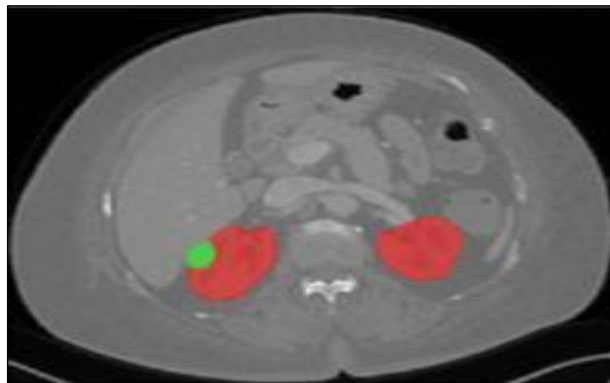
Images from Kits19 Data Collection Exhibiting an Axial Section across Patients' 3D CT Scans
